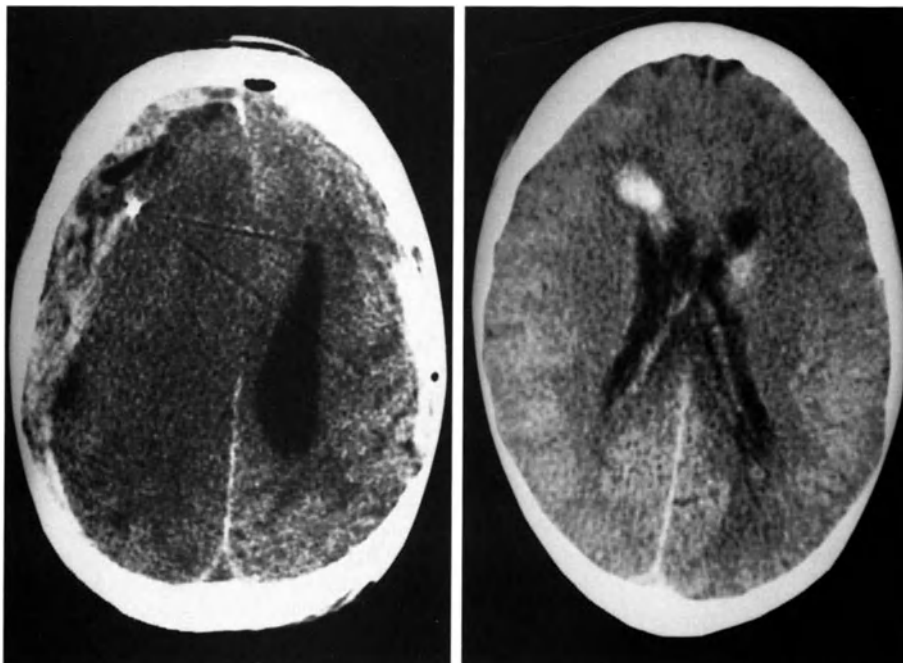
CT scan images of 2 ventriculostomy patients with intracranial hemorrhage complications
